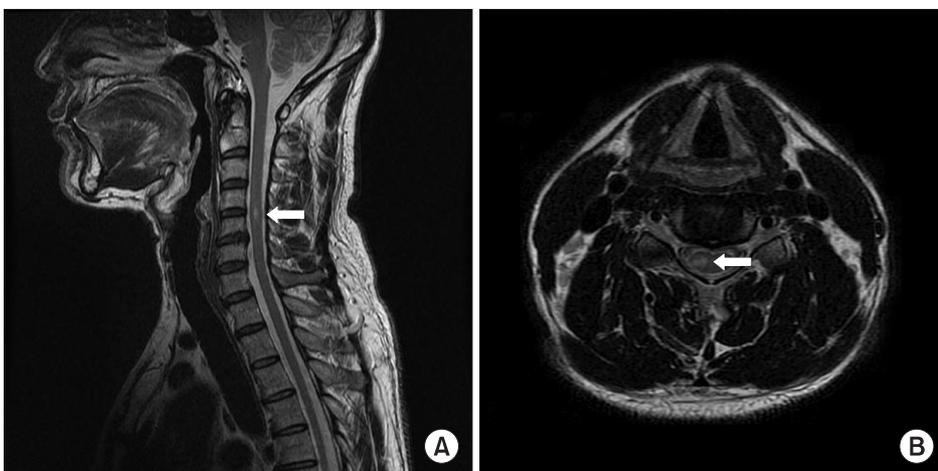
Magnetic resonance images of the cervical spine: T2-weighted sagittal image (A) and T2-weighted axial image (B) show 0.7 cm sized bright oval spot (arrow) on the right side of the spinal cord at the level of the C4-C5 disc.
